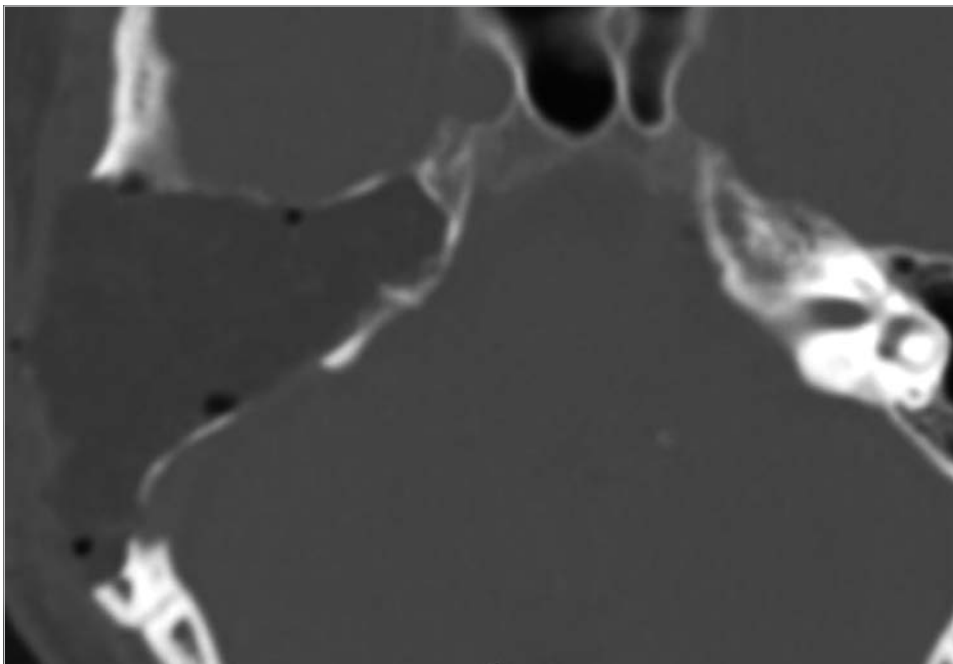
Postoperative CT shows complete removal of the inner ear.
